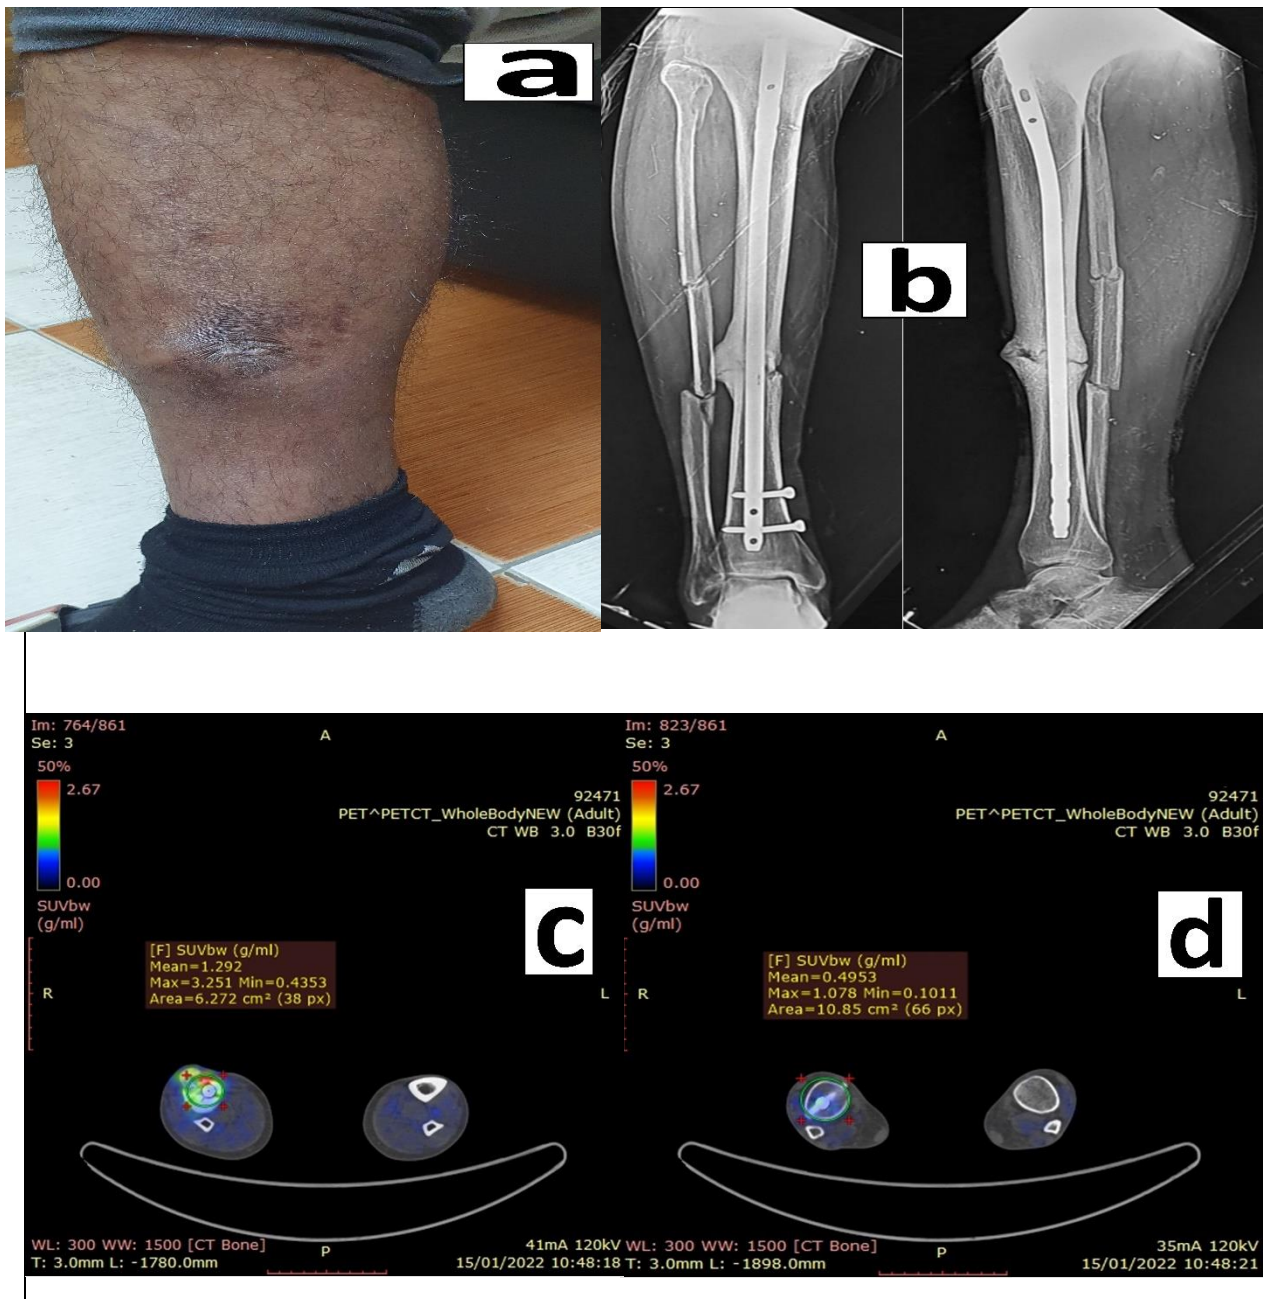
A 34-year-old smoker male (No. 1) had open grade II right tibial fracture treated by closed intramedullary nailing. Infection developed after 4.37 months of injury (a) The patient presented with infection duration of 11.4 months with a draining sinus (b) The radiographs at presentation (c) PET/CT SUV_{max} at the red zone (HUA) was 3.25. Three samples from HUA (fracture site) grew MRSA (d) At the green zone (LUA), SUV_{max} was 1.08. Three samples from the green zone (distal locking screws) grew Pseudomonas (i.e., different organism).
